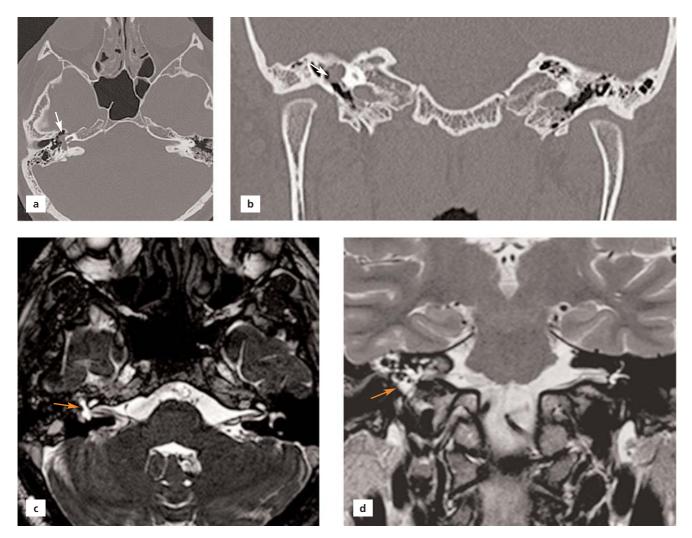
(a) Axial and (b) coronal MSCT sections of a 22-year-old male patient, meningocele pouch is located at the fissure line which crossed internal acoustic canal, labyrinthine part of the facial nerve and reached tympanic cavity (white arrows); (c) axial and (d) coronal T2-weighted MR images showing meningocele pouch in tympanic cavity (orange arrows).
